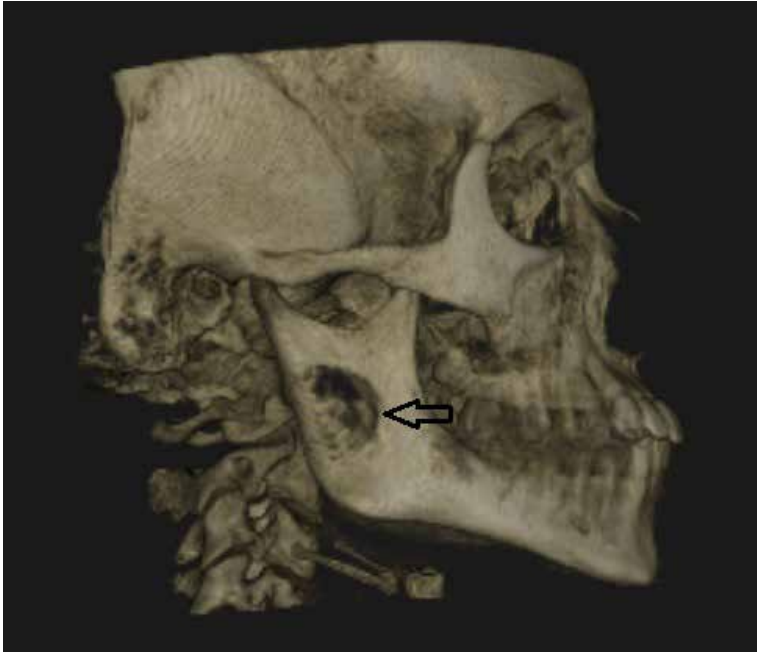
Panoramic view from CBCT scan (layer thickness 55.1 mm), August 2017. The arrow shows a lesion of significant dimensions, almost destroying the distal edge of mandibular ramus.
